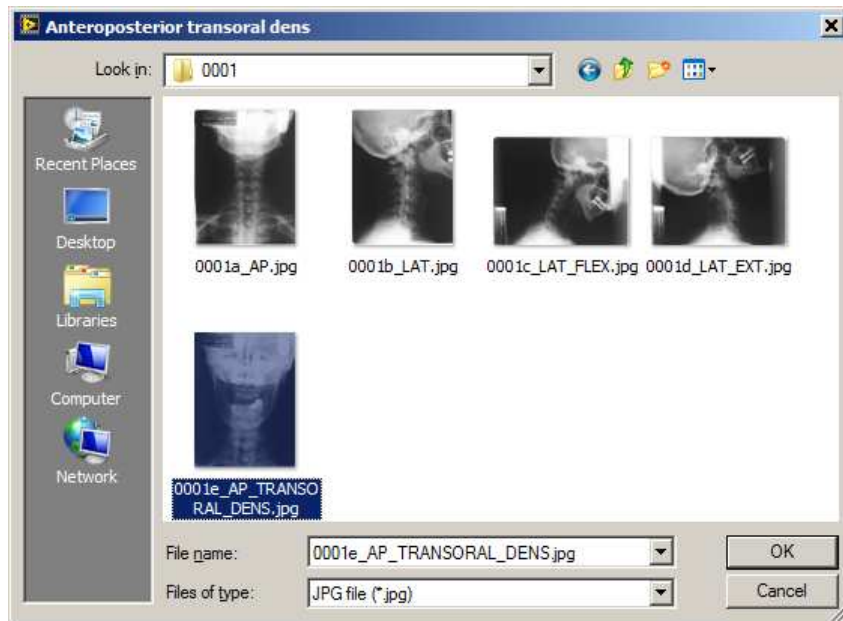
Selecting and opening JPG format radiographs one by one
